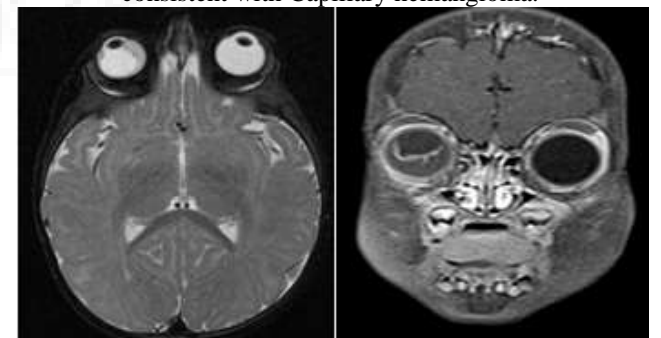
MRI Orbit show smaller sized right eye-globe with T2 intermediate signal along the inferior aspect with retinal detachment. No obvious post contrast enhancement seen (except margins)
